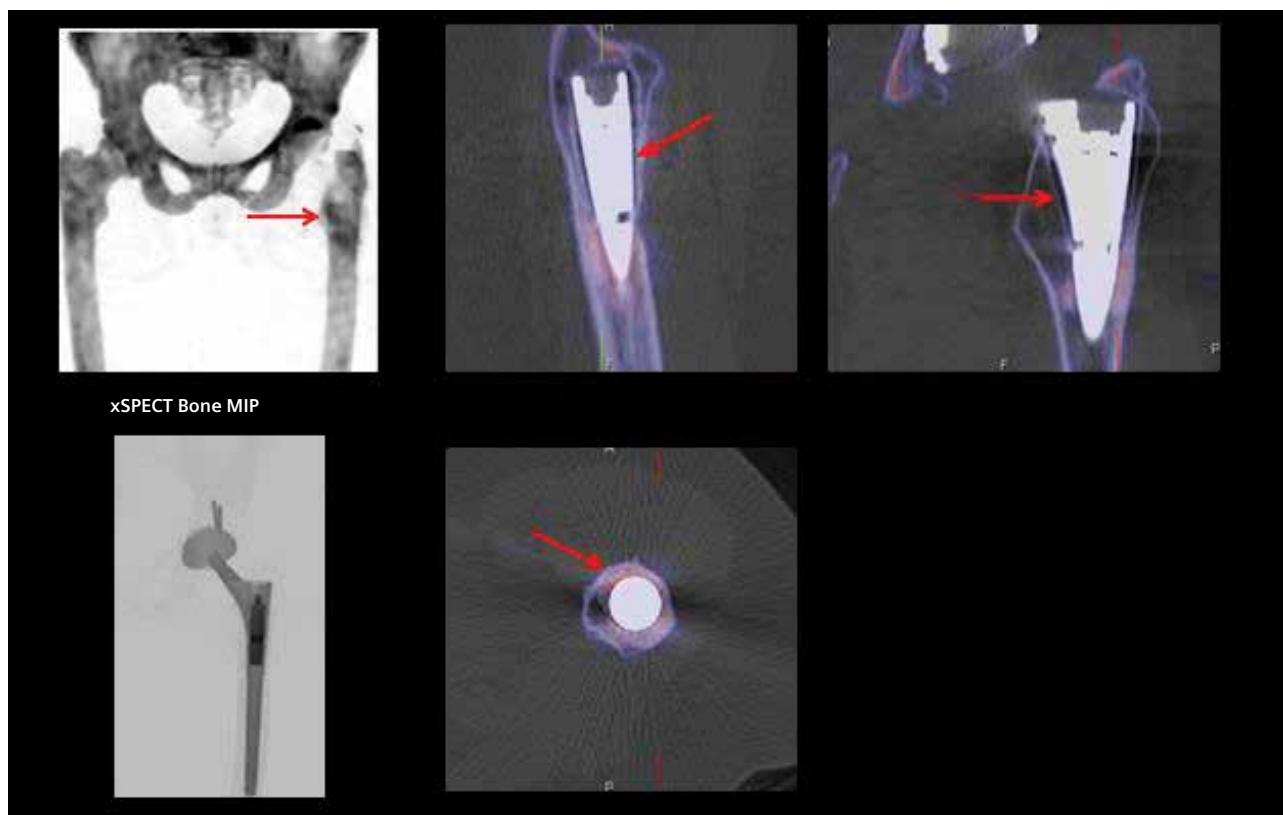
SPECT MIP image shows mild linear increase in uptake in the upper third of the femoral shaft and lesser trochanter. Fused xSPECT images show radiolucent zones between the margin of the prosthesis and adjacent bone (*thin red arrows*), with part of these zones showing mild increase in uptake, which suggests bone stress related to loosening.
